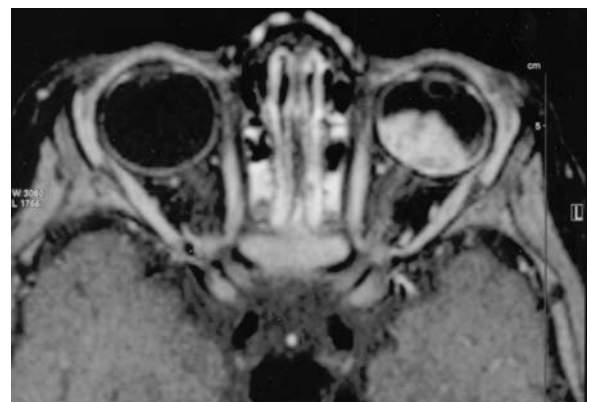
T1/fat suppression axial MRI. Left intraocular tumor corresponding retinoblastoma. CT (not shown) with dense calcification
